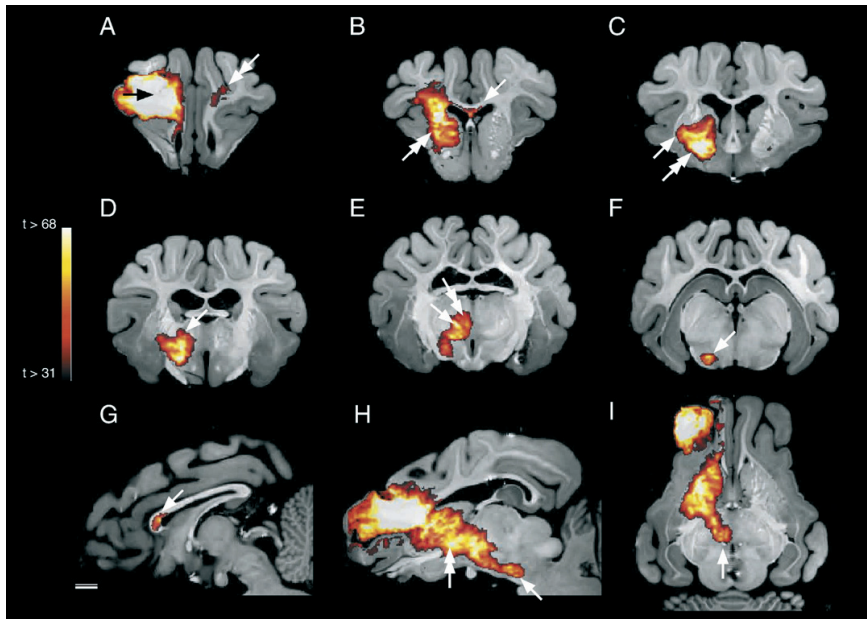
In vivo tracing using manganese injected into the right SC of brain 1. Pathways of the manganese labeling are represented by the statistical t -map (color bar) visualized on the high resolution in vitro MPRAGE MRI seen in coronal (A–F), sagittal (G, H) or horizontal section plane (I). The right side of the brain is depicted in the left side of the figures. The frontal injection site in the SC (A, arrow) with corticocortical pathway towards the contralateral SC (A, double arrow) is seen crossing through the genu of the corpus callosum (B, G, arrow). Ipsilaterally, manganese is seen in the internal capsule (B, H, double arrow), parts of the putamen (C, arrow) as well as the pallidum (C, double arrow). Several segregated pathways were observed; one pathway enters the ventral thalamus (D, arrow) with manganese labeling in the VP (E, I arrow), as well as parts of the MD nucleus of the thalamus (E, double arrow). Another pathway was detected more ventrally oriented towards the subthalamic nucleus (E) and the SN (F, H, arrow). Scale bar = 5 mm.
